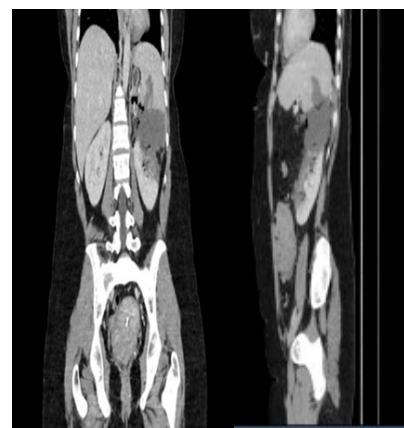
CT imaging of lobulated heterogeneous mass in the left adrenal gland was 16.7 x 11 cm in size and had several linear calcifications within the mass.
